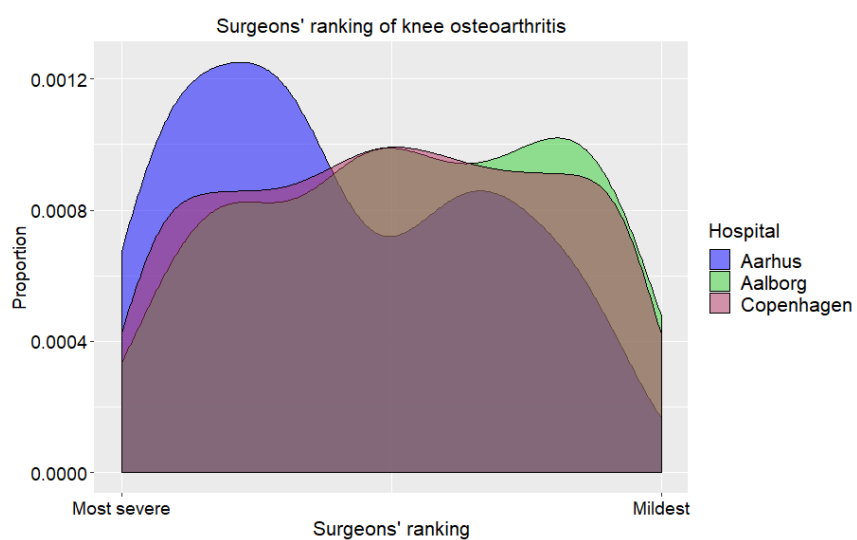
Abbreviations: K-L = Kellgren-Lawrence. Surgeons' ranking = 13 surgeons' ranking of radiographic knee OA severity, total range 1- 1051 (1 is most severe).
